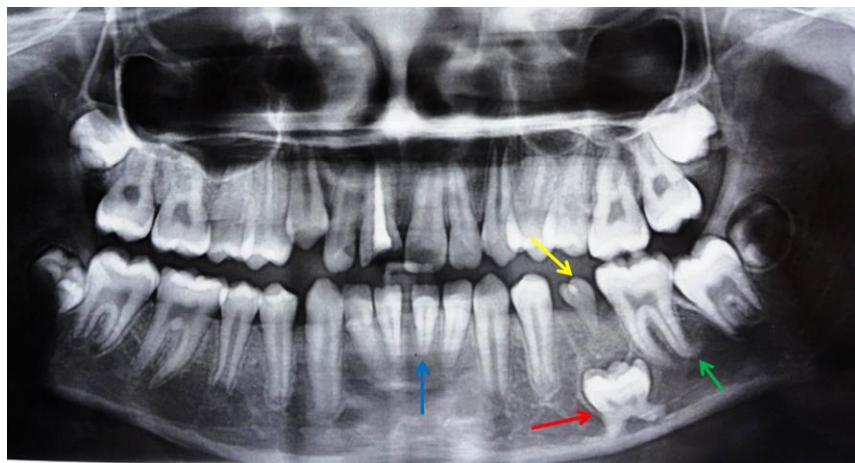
Orthopantomograph showing rudimentary, anomalous mandibular second premolar with short root (mimicking flower bud) (yellow arrow), ankylosed primary second molar (red arrow), and short root anomaly in lower left central incisor (blue arrow) and root dilaceration (90-degree bend) in left permanent first molar (green arrow).
